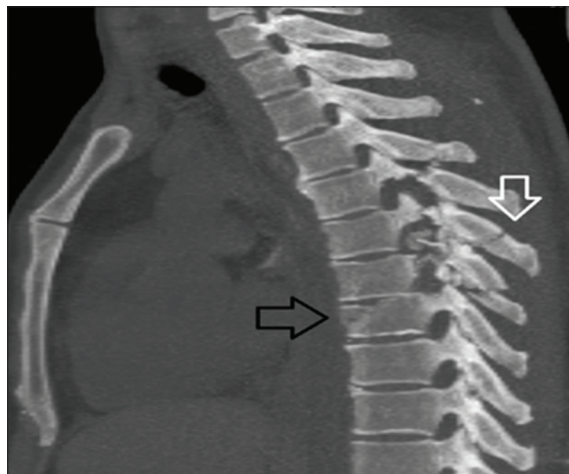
Non-contrast computed tomography chest bone window sagittal view demonstrates thoracic vertebral body fracture (black arrow). Associated posterior elements fracture (white arrow) is also noted
